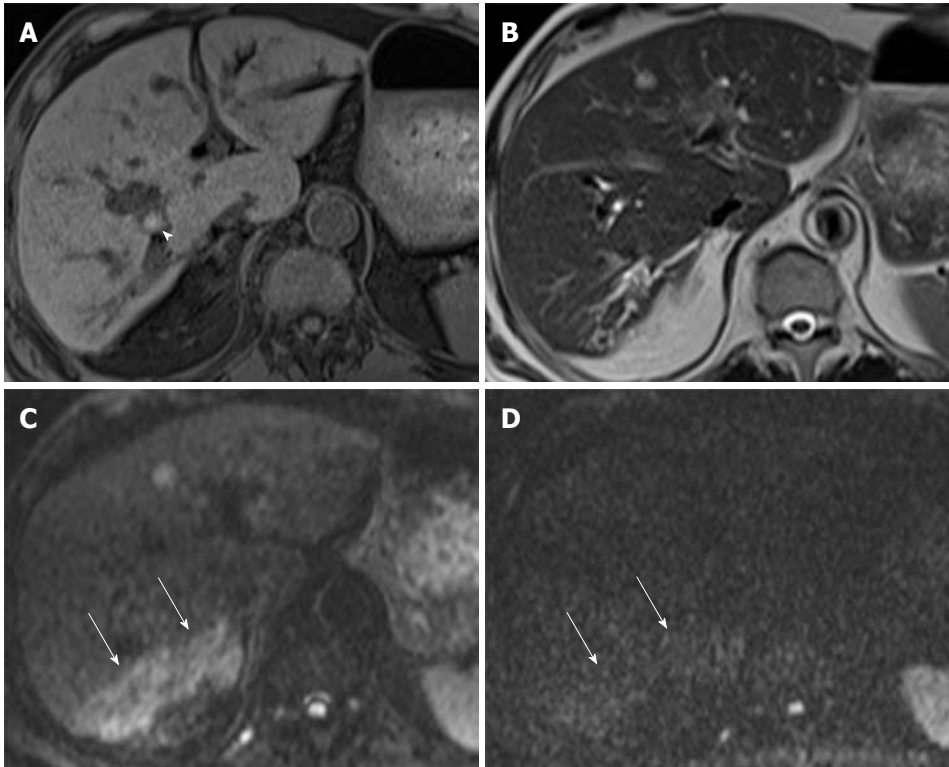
Parenchymal changes in acute cholangitis in a 76-year-old man. A: Axial fat-saturated T1-weighted image shows a hyperintense stone (arrowhead) with upstream bile duct dilation; B: Axial T2-weighted rapid acquisition relaxation enhancement image shows mild bile duct dilatation in the right lobe of the liver, but no definite area of increased parenchymal signal intensity; C: DWI at $b = 50 \text{ s/mm}^2$ shows wedge-shaped areas of increased parenchymal signal intensity in segment 6 (arrows). Parenchymal changes are more conspicuous on black-blood images than on routine T2-weighted images; D: DWI at $b = 800 \text{ s/mm}^2$ shows that most areas of increased parenchymal signal intensity usually return to isointensity (arrows). Such a finding can be a clue for differentiating parenchymal changes due to cholangitis from abscesses. DWI: Diffusion-weighted magnetic resonance imaging.
